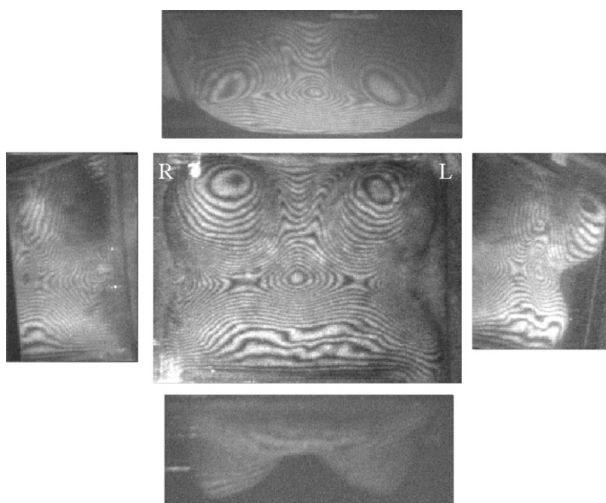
Five holographic images of a normal subject: Five different views are captured from each hologram: superior (corresponding to cranio-caudal view of x-ray mammogram), two lateral, a frontal and an inferior views. R and L marked on the holographic images indicate right and left lateral aspects of the subject's thorax. The same definitions are used for Figure 8. Subjects of these holograms were known not to have any tumors in the breasts.
